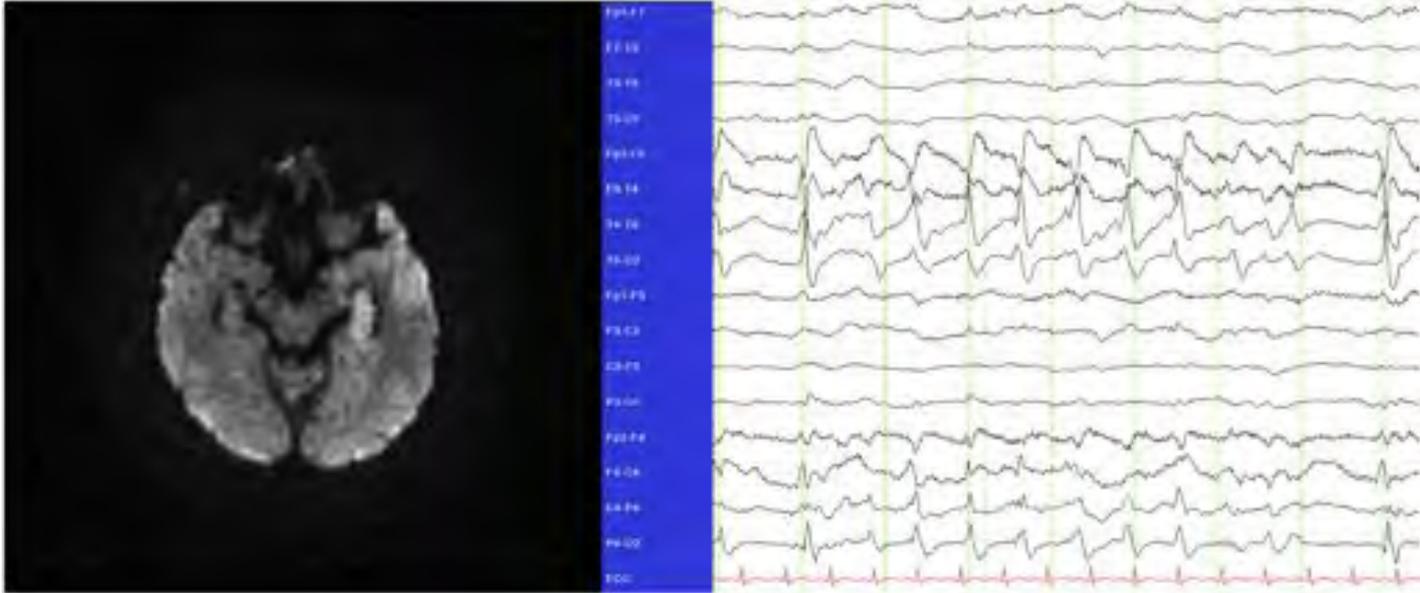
DWI-MRI and EEG from an 81-year-old woman with HSV-1 encephalitis and status epilepticus. The DWI images demonstrate restricted diffusion in the left temporal lobe. The corresponding EEG shows lateralized periodic epileptiform discharges with additional faster activity (LPEs+), indicating a very high risk of subsequent electrographic seizures.
